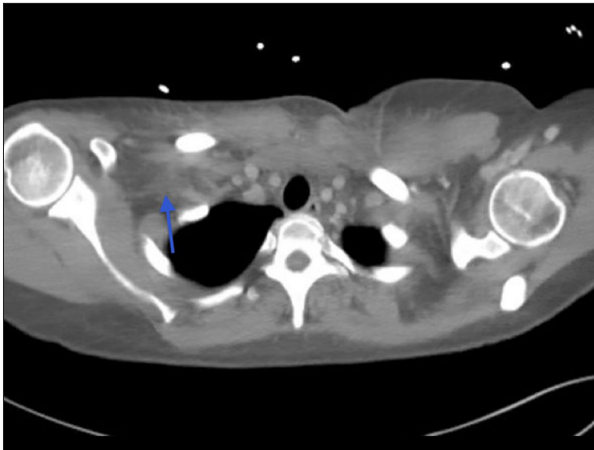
Shoulder CT with IV contrast reveals edema and fluid anterior to the right sternoclavicular joint with involvement of the right anterior thorax (arrow).
